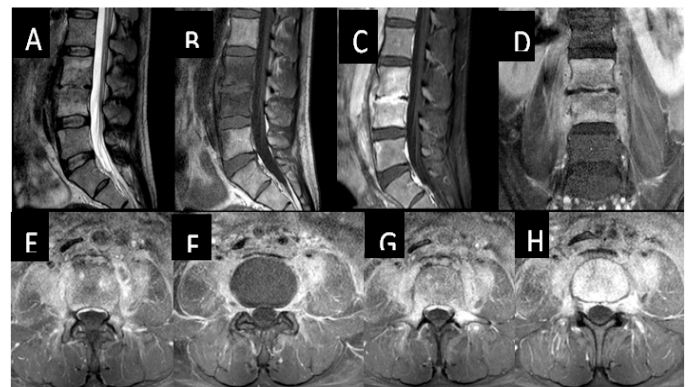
Spine MRI revealed bone marrow edema (A) and contrast enhancement of the L3 and L4 vertebral bodies, pedicles, pars interarticular, facet joints, and intervertebral disc (C, G). Inflammatory changes and enhancement of the adjacent psoas (D) with small intramuscular abscesses (E).
